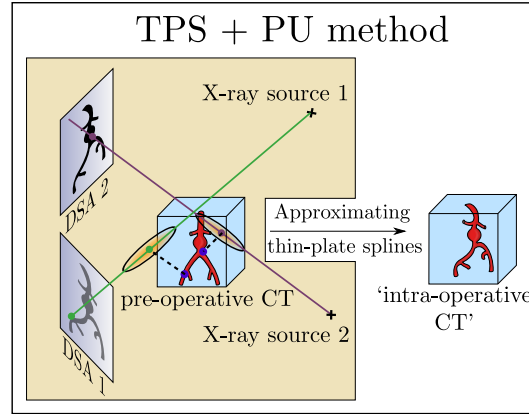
Thin-Plate Splines + Projection Uncertainties: 3D source points are picked on the aorta surface, corresponding 2D target points are picked within the two DSA images. 3D target points are computed as the closest points to 3D source points on the back-projection lines that join the X-ray source and the 2D target points. Projection uncertainties take the form of ellipsoids, with a main axis which lies on the back-projection lines and two secondary axes with a 0 length. Registration is carried out using the 3D source points, 3D target points and error ellipsoids.
